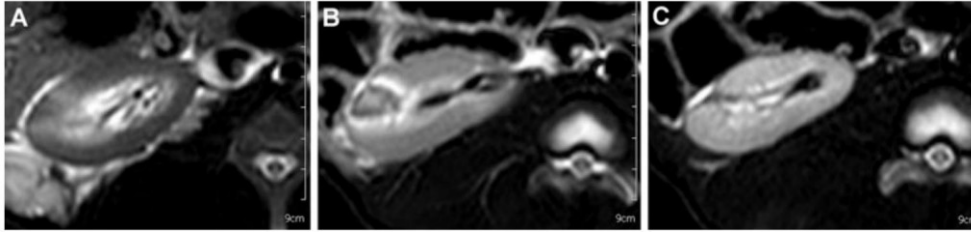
MRI of the center part of the right kidney at 30 min (a), 7 days (b), and 28 days after NTIRE (c)<sup>76</sup>
